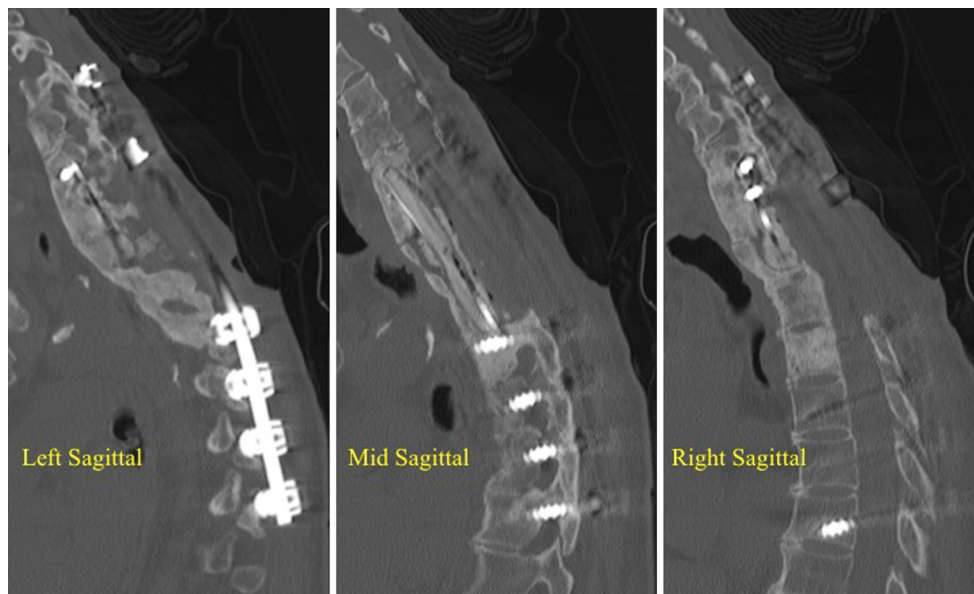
CT Scan of the thoracic spine 13 years following initial intervention showing the anterior PMMA spacer incased in bone
